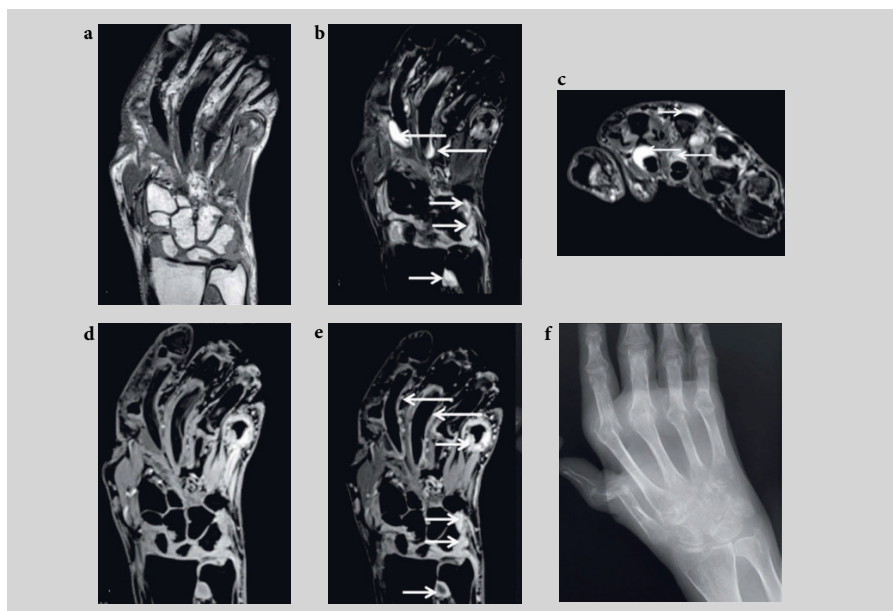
Magnetic resonance imaging (MRIs) and X-ray of the hand and wrist of patient with rheumatoid arthritis with ulnar deviation and luxation of the metacarpophalangeal joints due to advanced severe disease. The displayed MRIs are (a) coronal T1-weighted; (b) coronal short tau inversion recovery (STIR) ; (c) axial STIR (through metacarpals); and coronal T1-weighted fat-suppressed before (d) and after (e) intravenous contrast injection. On top of ulnar deviation of the fingers, due to severe damage, MRI reveals marked synovitis in both wrist and metacarpophalangeal (MCP) joints (short arrows), as well as tenosynovitis in the second and third flexor tendons (long arrows). The corresponding hand and wrist X-ray (f) shows severe destruction in the MCP joints.
